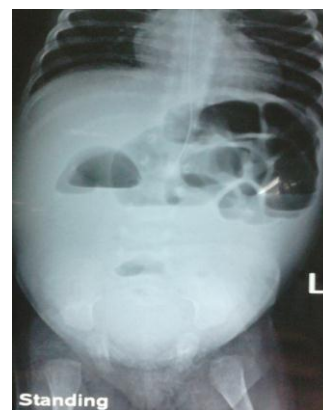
An erect radiograph in a neonate with ileal atresia showing multiple air fluid levels with no gas beyond.
